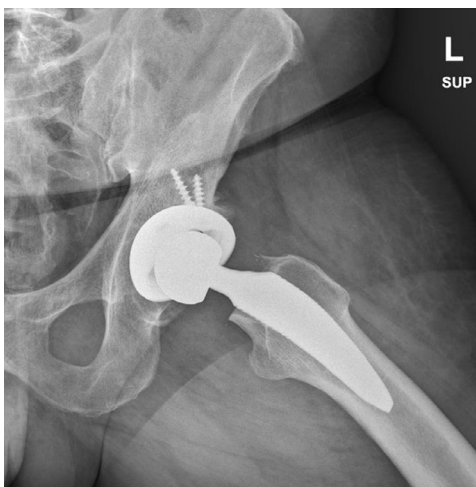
AP and lateral radiography at last follow up. Trabecular bone surrounding implant.
